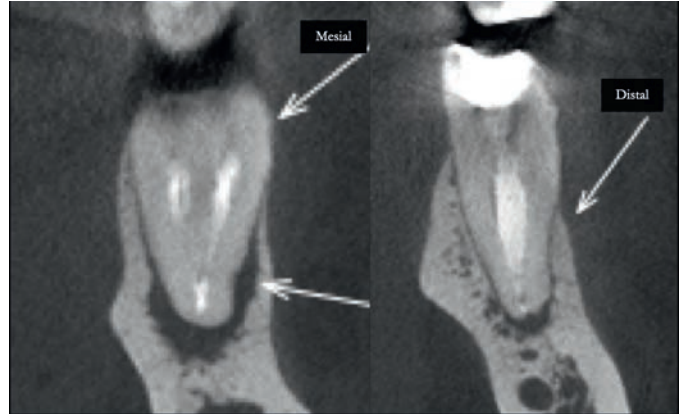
CBCT coronal images.
